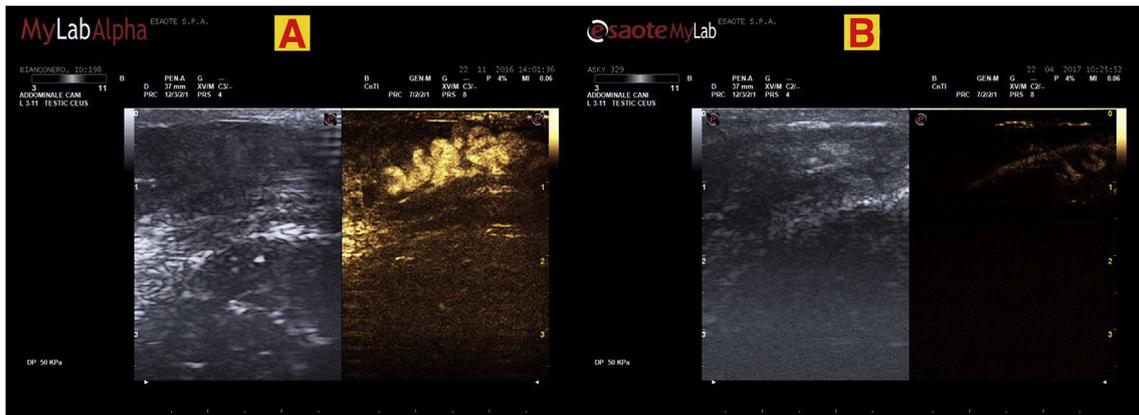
Ultrasonography on the left, CEUS on the right. A: The normal epididymis at T₀. The grey-scale ultrasonography shows a normal aspect of epididymal tubule enhanced by the passage of microbubbles. B: Intraepididymal CaCl₂ injection (group IEca) at T₅. Reduced epididymal perfusion. The grey-scale ultrasonography shows the epididymis without perfusion and completely anechoic.
